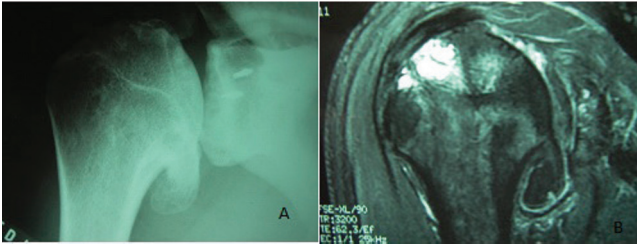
A) Radiograph in true AP view on the right shoulder, showing large lower osteophyte in the humeral head, preservation of the joint space and presence of metal anchors from previous surgery on the glenoid; B) NMR T2 image with fat suppression – presence of large lower osteophyte and subchondral cysts in the humeral head; tendon of supraspinatus preserved in its insertion.
